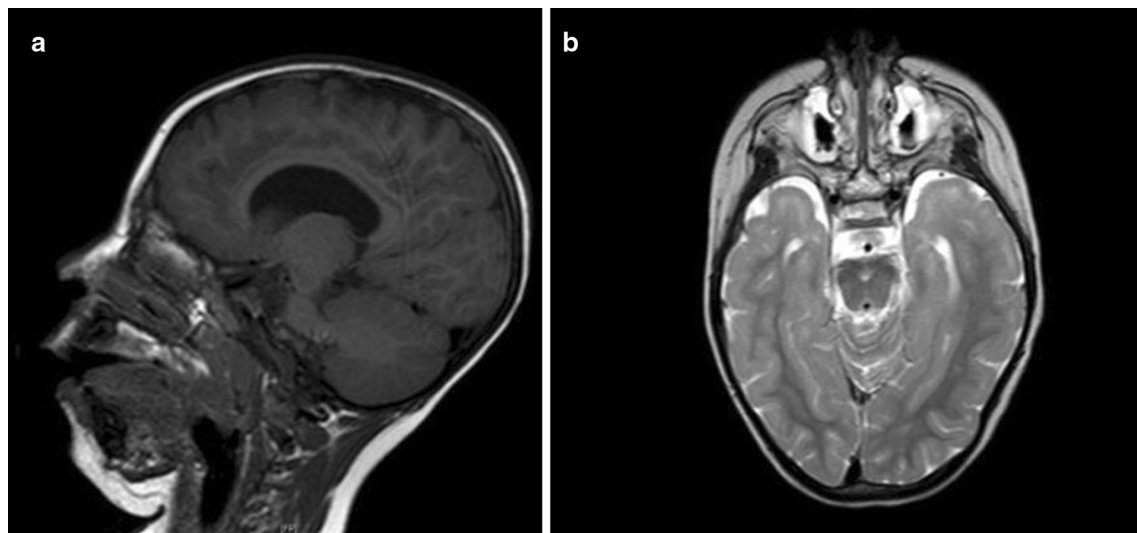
Brain MRI of patient 1 at 32 months of age. a Sagittal and b axial images showing pachygyria and microcephaly
